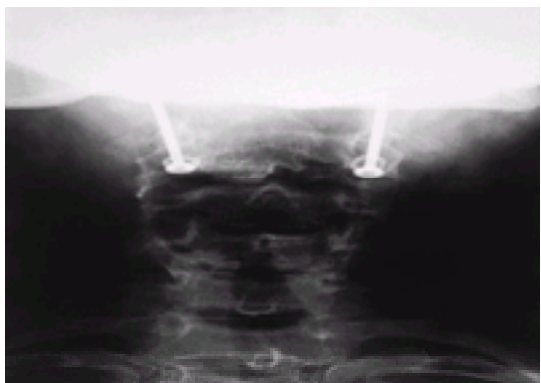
Radiography showing transarticular screw fixation—C1, C2.
